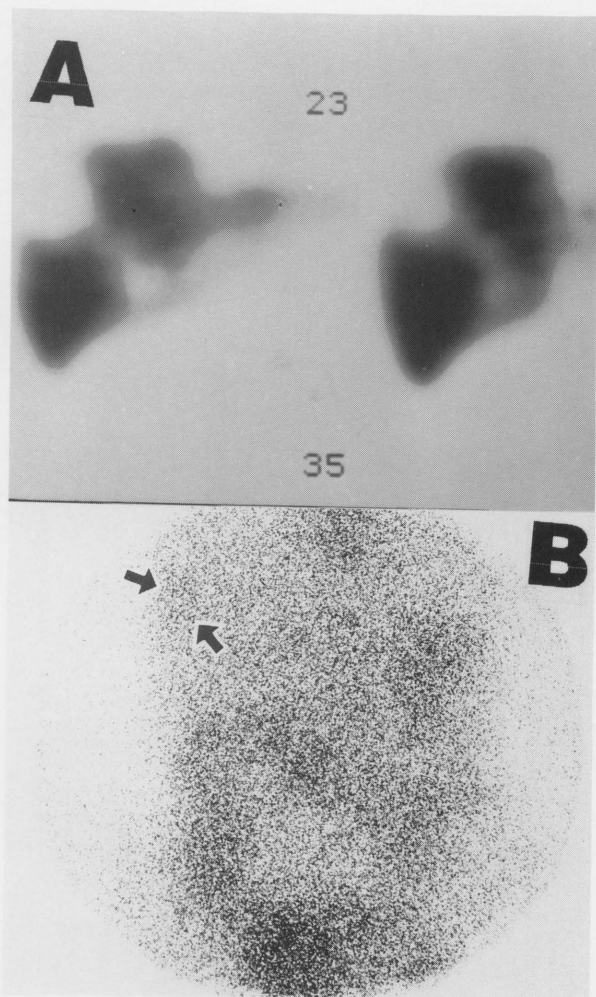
(A) Colloid liver SPECT imaging of the patient with liver metastasis shows tumor at superio-lateral aspect of right lobe of liver. (B) Immunoscintigraphy shows increased activity at the region of tumor (arrows) compared to the surrounding normal liver tissue.
